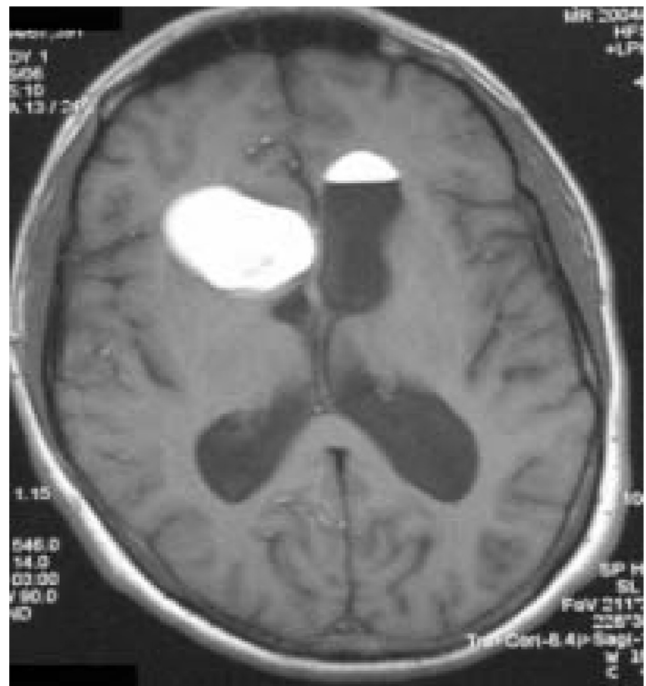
Preoperative axial T1-weighted MRI slice revealing the right frontotemporal dermoid cyst, fat-fluid level in the contralateral ventricle and diffuse subarachnoid dissemination of fat droplets notably in the right frontal lobe.
